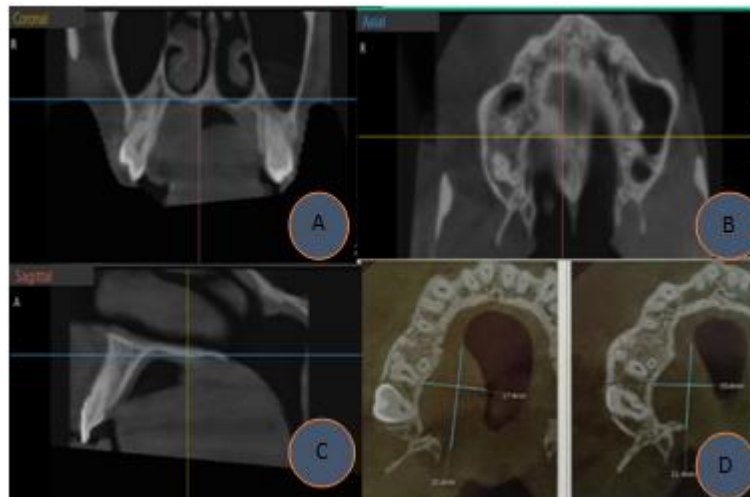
A, B, C Showing CBCT of maxilla showing presence of lesion in coronal, axial and sagittal section - no bony resorption, intact nasal floor and no involvement into nasal cavity and antrum. Fig - 5 - D showing dimension and extension of lesion in axial view.
